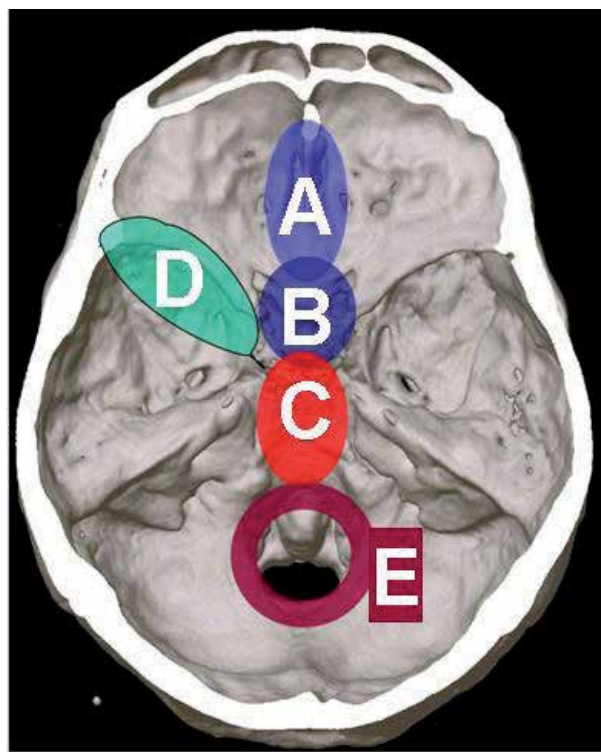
Computed tomography of the skull base with marked areas of meningioma occurrence, A: olfactory groove, B: para-, suprasellar, C: petro-clival, D: sphenoid wing, E: foramen magnum.
